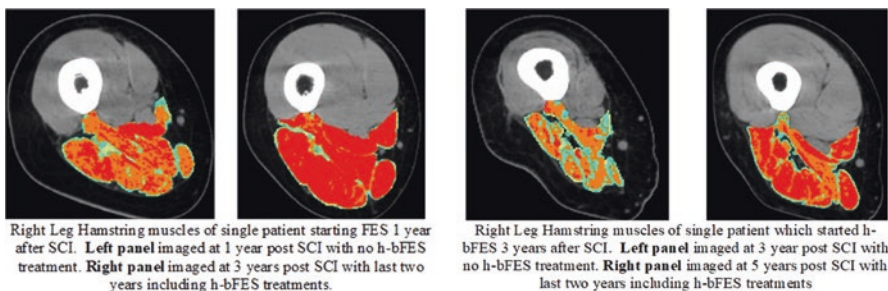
Muscle color computed tomography of thigh muscles at 20 cm from femur head. Both the quadriceps and the hamstring muscles increased in size and tissue density (improved content of the red healthy muscle fibers) after 2 years of training using the Vienna protocol for h-bFES of permanently denervated human muscles. Comparison of the left and right left panels provides strong evidence of the deterioration that occurred in the long-term denervated muscles between the first and the third year post SCI. However, it is worth noting that, even starting 3 years post SCI, h-bFES is able to recover substantially the hamstring muscles
